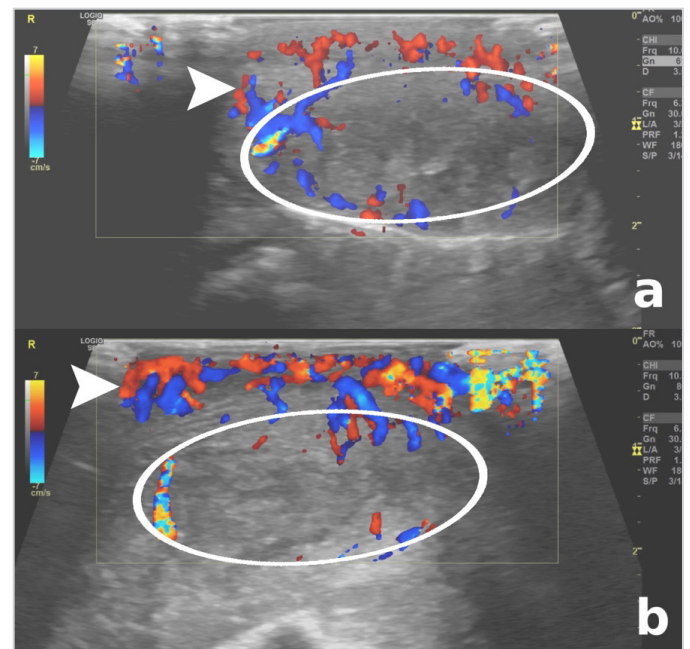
In the ultrasonographic examination of the lip, a marked increase in lip thickness, a heterogeneous collection with a dense content compatible with abscess in the central part (circles), and b. increased vascularity in the periphery with Doppler sonography are observed (arrowheads)
